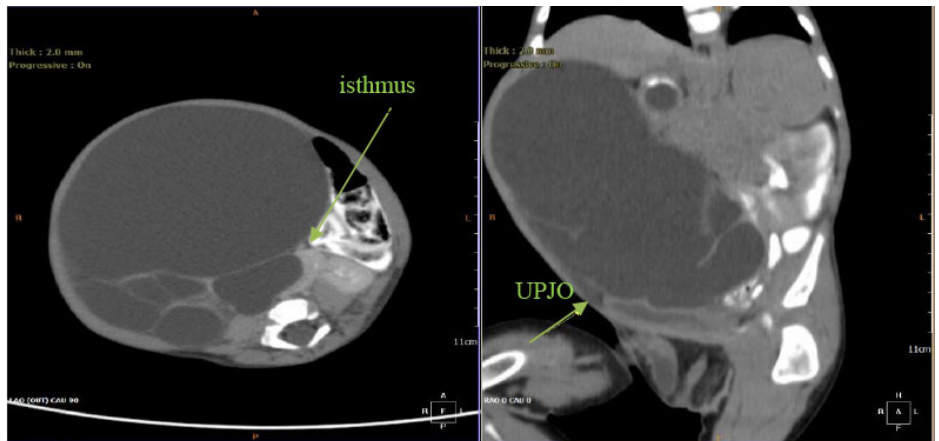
CT abdomen showing Right severe hydronephrosis with UPJO.
